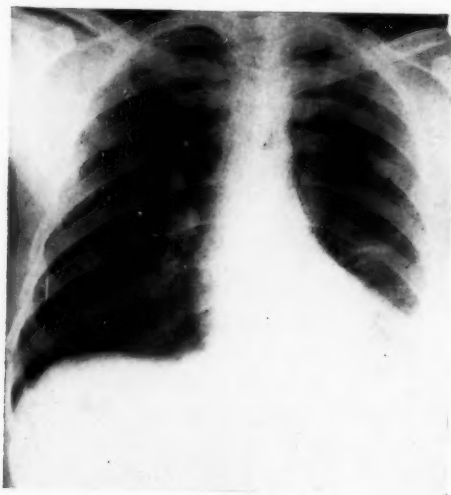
X-ray showing end-result on case 2.
